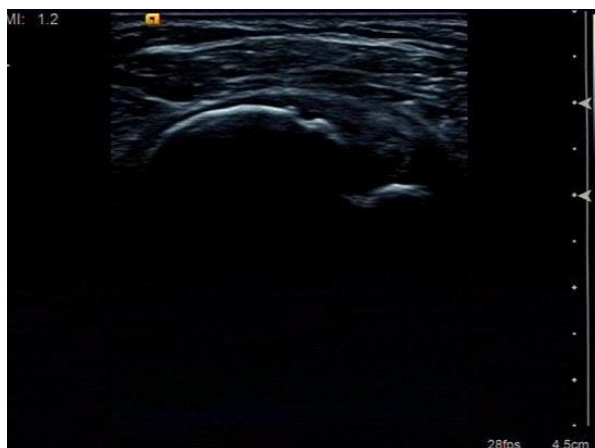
Sonogram of drug injection after shoulder joint cavity
